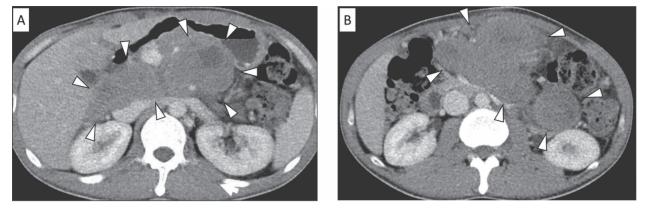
(A, B) Contrast-enhanced computed tomographic examination 2 months after surgery showed multiple tumors (white arrowheads) in the abdominal cavity.
